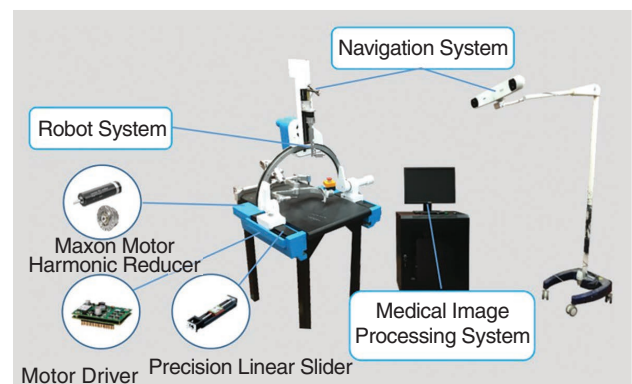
A potential robot for liver and kidney interventions, with an arch gantry (a non-MRI-compatible robot) From [163]; used with permission.
